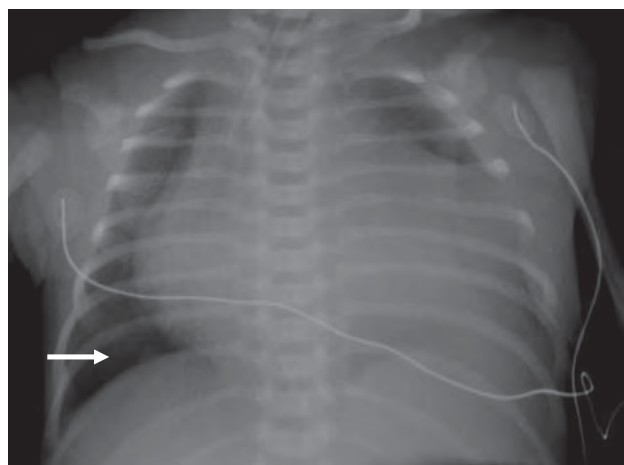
Frontal radiograph of the chest in a patient with Ebstein anomaly shows decreased pulmonary vascularity and marked cardiomegaly. Notice how clear the lungs are with very few vessels seen (arrow).
